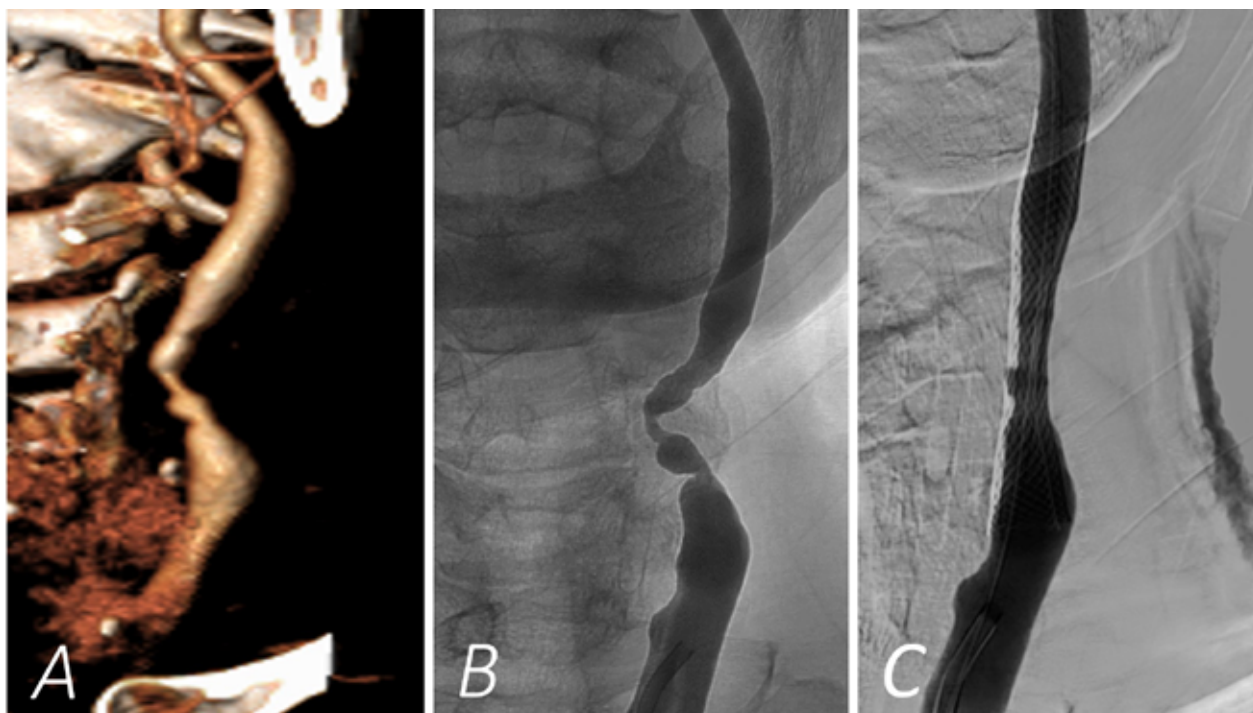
A) 1-year after left carotid venous bypass grafting CTA exam that confirmed the presence of a hemodynamically significant restenosis of the first segment of left carotid venous graft, just above the proximal anastomosis. B) A selective left carotid DSA was performed, confirming the presence of a left significant carotid graft stenosis. C) A post-procedural DSA, showing there were not residual stenosis, neither contrast collection outside the venous graft.
